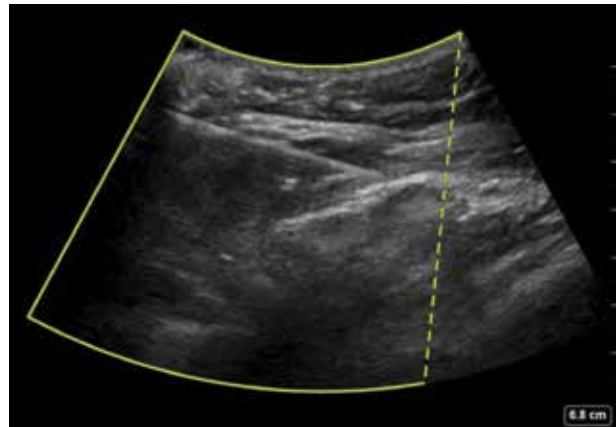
Ultrasound-guided superior cluneal nerve (SCN) block. Left side of image is lateral; right side is medial. The SCN is located deep in the hyperechoic fascial plane.
